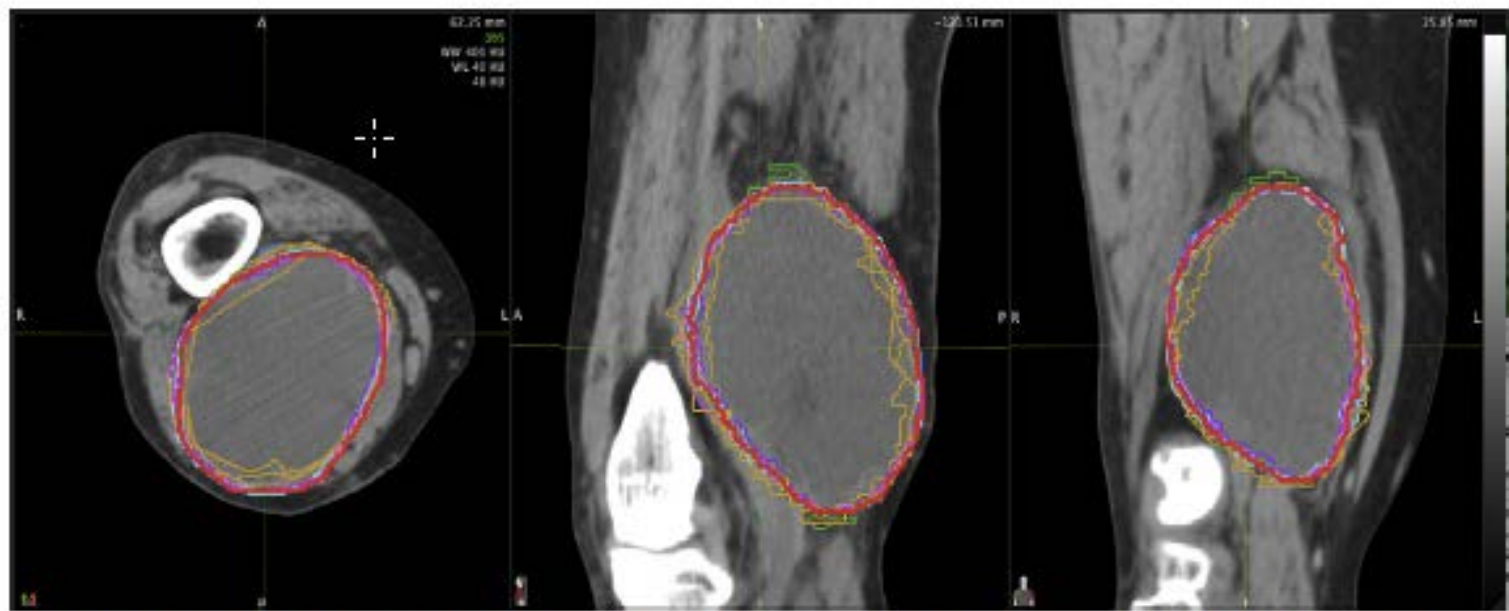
Example of individual and consensus (red) contours of gross tumor volume on axial computed tomography for patient with large high-grade sarcoma of distal aspect of right thigh.
